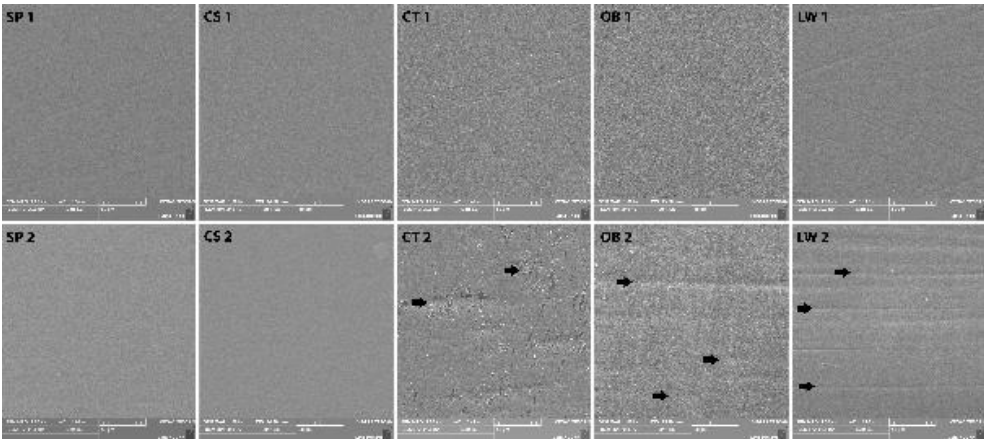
Representative SEM images of the Cerasmart material, with a magnification of $\times 1000$, from before (1) and after brushing (2) with sensitivity (SP and CS), regular (CT), and whitening (OB and LW) toothpastes. The black arrows point to the cracks or scratches caused by brushing.
